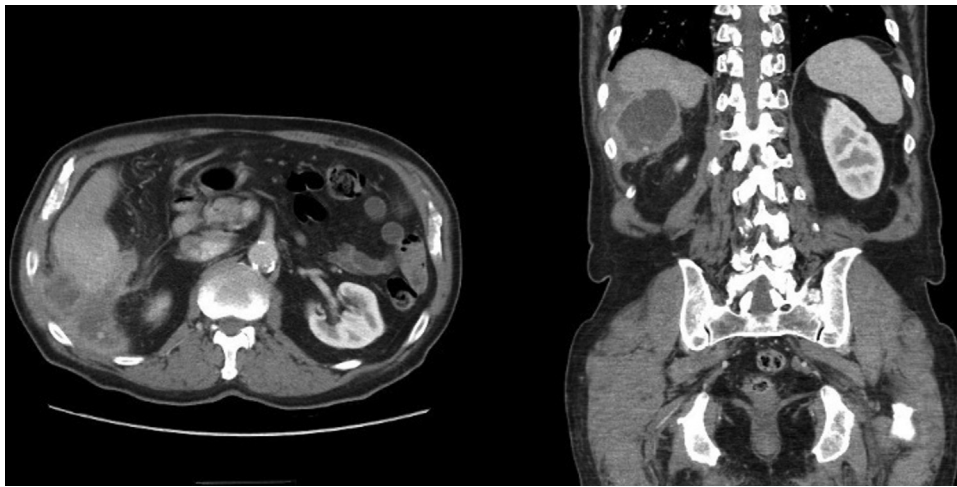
CT scan of abdomen pelvis with intravenous (IV) contrast showed moderate volume encapsulated fluid collection overlying the lateral and posterior right hepatic lobe measuring $5.4 \times 12.2 \times 7.2$ cm with a thin extension tracking anteromedial to the gallbladder fossa and contiguous with the cystic duct remnant. There was one and possibly a few hyperdense foci in the dependent portion of the fluid collection measuring up to 7 mm.
